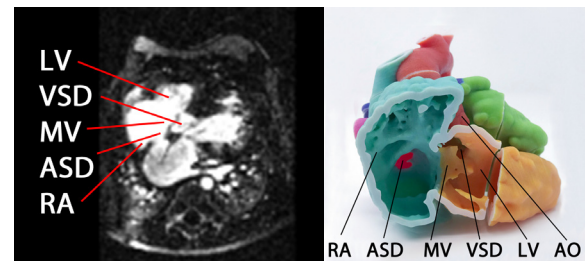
MRI and 3D model of a 5-day old infant with congenitally corrected transposition of the great arteries with a large ventricular septal defect and severe subaortic stenosis. (AO – aorta, ASD- atrial septal defect, RA – right atrium, LV – left ventricle, MV – mitral valve, VSD – ventricular septal defect).
